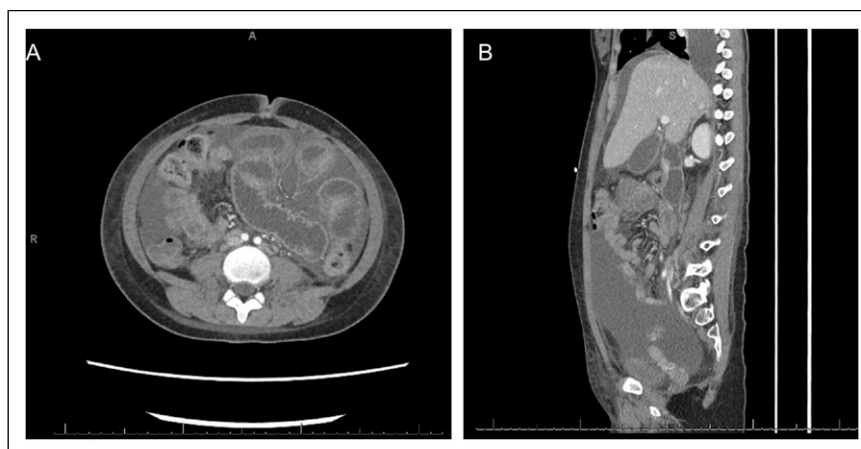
CT of Abdomen and Pelvis. (A) Axial and (B) sagittal views demonstrating severe bowel wall thickening throughout entirety of jejunum and ileum with a transition to decompressed right lower quadrant small bowel, demonstrative of mechanical small bowel obstruction with bowel wall thickening suggestive of ischemia.
